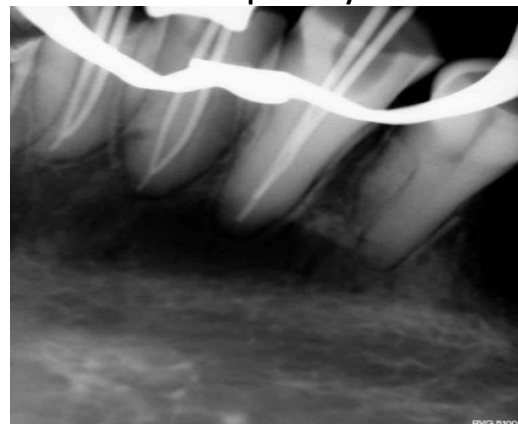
Master Cone Radiograph Of 41,42 And 43 Respectively
